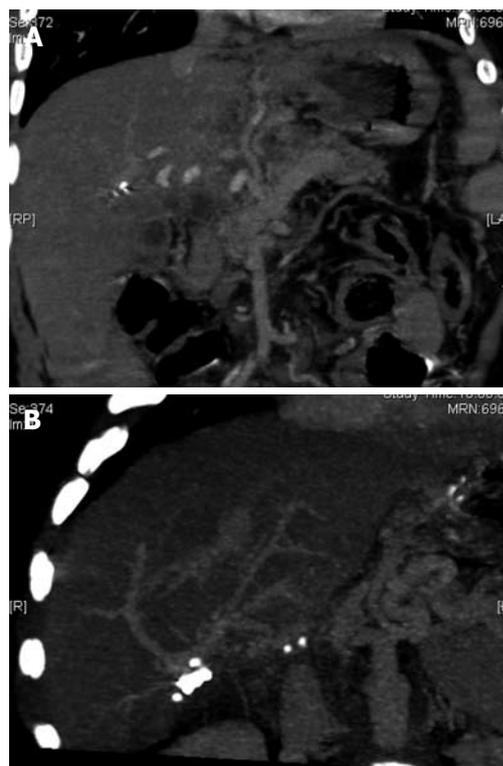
Portal vein thrombosis. Computed tomographic angiography with evidence of portal vein thrombosis and cavernomatous degeneration with collateral drainage through the left gastric vein (A), and evidence of intrahepatic portal flux restoration (B).
